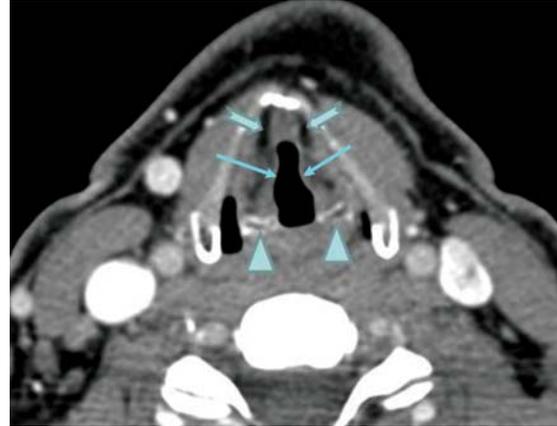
Axial CT scan through the supraglottis at the level of false cords (arrows). The arytenoid cartilages (arrowheads) are seen posteriorly. The paraglottic space at this level contains mainly fat (notched arrows)
